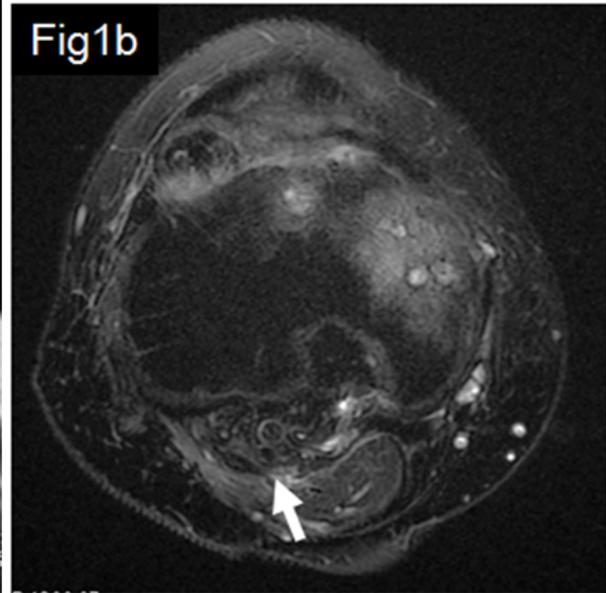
Pre-treatment MRI (Fig1a: sagittal image, Fig1b: axial image) showed the recurrent PVNS around the popliteal fossa (white arrow). Fig.2: Post-treatment MRI (Fig2a: sagittal image, Fig2b: axial image) showed the mild shrinkage of tumor (white arrow).
